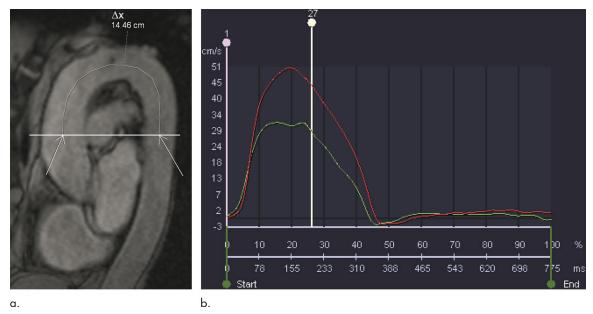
(a) Δx measurement on the parasagittal "candy-cane" gradient-echo MR image. The white line represents the reference plane of through-plane phase-contrast images. (b) Ascending (green) and descending (red) aortic mean velocity curves used to fit two normalized sigmoid curves to their systolic upslope to delimit minimized area between them for Δt calculation by transit time—upslope method.
